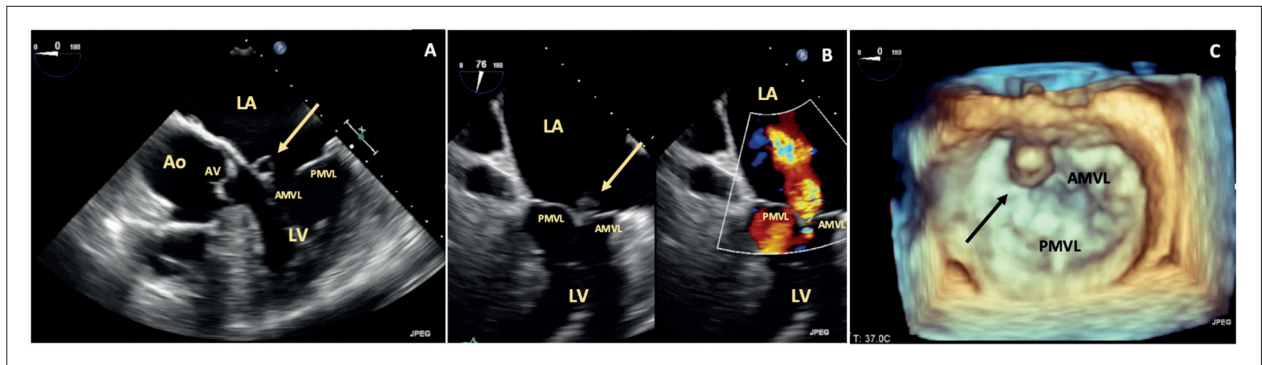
A) 2-D Transesophageal echocardiographic evaluation depicting a saccular bulge in the anterior mitral valve leaflet with systolic expansion towards the left atrium, suggestive of a leaflet aneurysm (→); B) Moderate mitral regurgitation (grade II/IV) through the aneurysm of the anterior mitral valve leaflet; C) 3-D Transesophageal echocardiographic evaluation, “en-face” view showing the saccular bulge located on the anterior mitral valve leaflet corresponding to the leaflet aneurysm (→). AMVL: anterior mitral valve leaflet; Ao: aorta; AV: aortic valve; LA: left atrium; LV: left ventricle; MV: mitral valve; PMVL: posterior mitral valve leaflet.
